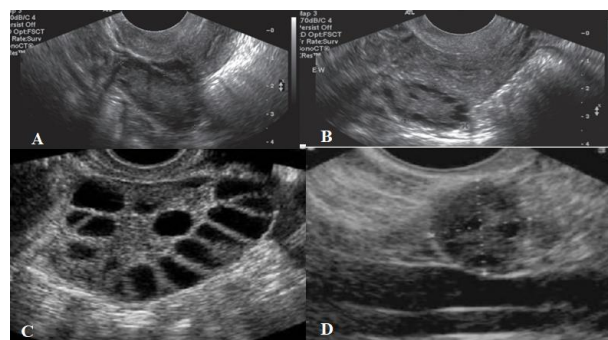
Ultrasonography showing PCOS.^{12,13}
